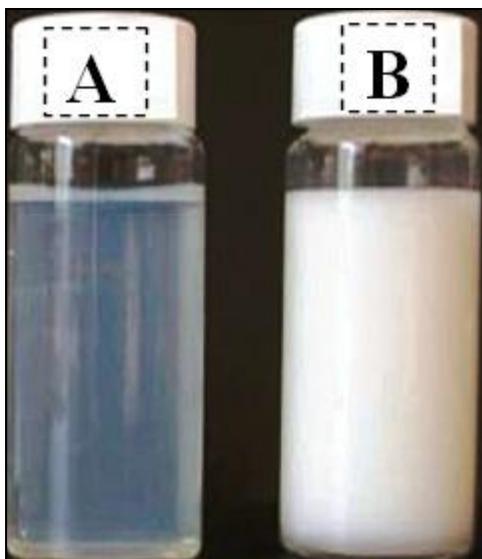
(A) NANOEMULSION AND (B) MACROEMULSION WITH DROPLET DIAMETERS OF LESS THAN 100 NM AND MORE THAN 1000 NM, RESPECTIVELY⁵
